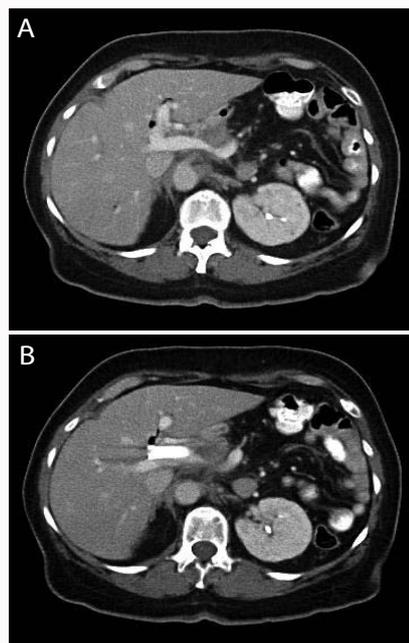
Post-FOLFIRINOX (11-20-2015) CT images showing (a) a decreased narrowing of the portal vein and (b) a clear fat plane with the tumor regressing from the SMV.
